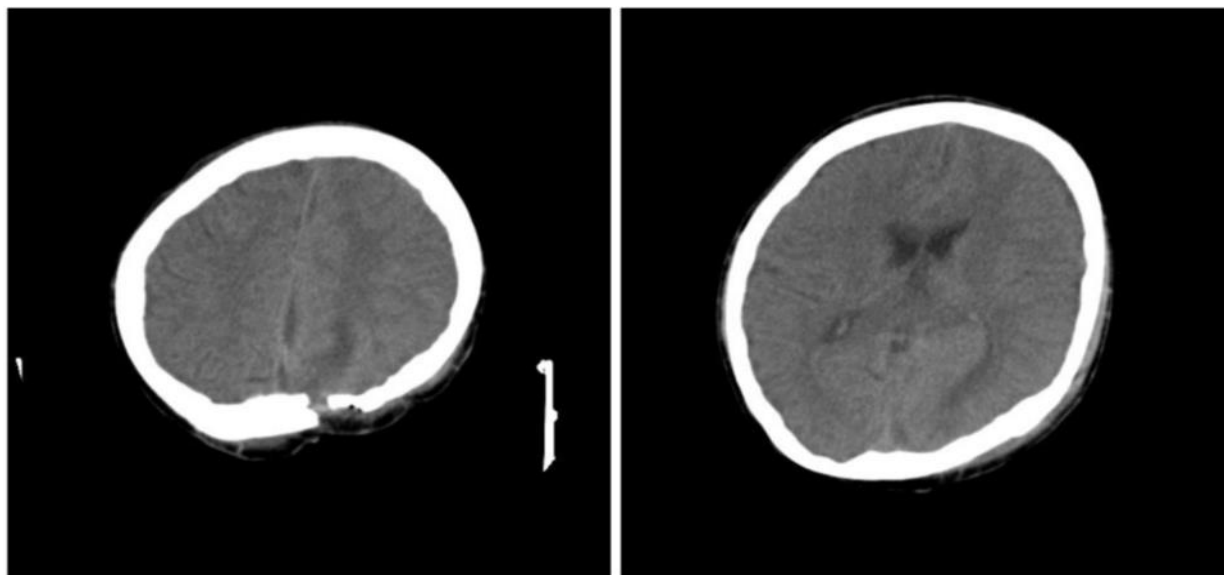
CT scan after operation
